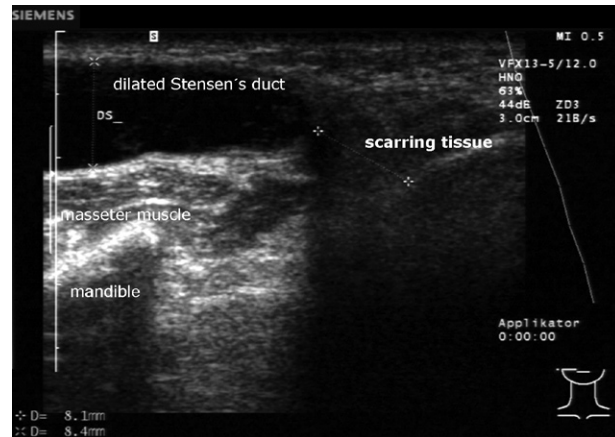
Ultrasound shows dilated Stensen's duct ("mega-ductus") due to stricture of papilla. Extent of scar can be measured exactly (10 mm).
